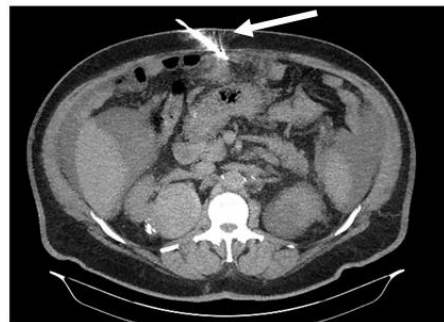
CT-scan guided biopsy of the peritoneal fat (arrow)
